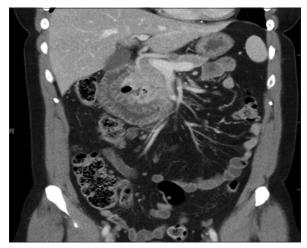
Computed tomography abd/pelvis coronal view
